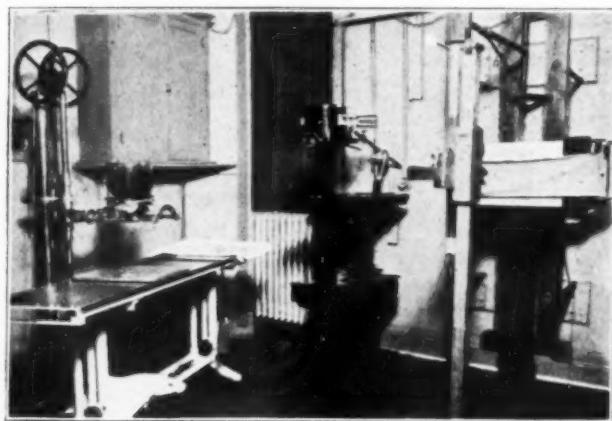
The examination room, x-ray department, Bellevue Hospital, New York City, showing the three working units. To the left, the table and tube stand for examination of patients in the horizontal position. In the center, the vertical tube stand arrangement to examine the upper extremity of walking patients. To the right, a vertical arrangement for the making of plates of chests and stomachs. The tube stand here may be slid out for a distance of six feet for special plate examination.
